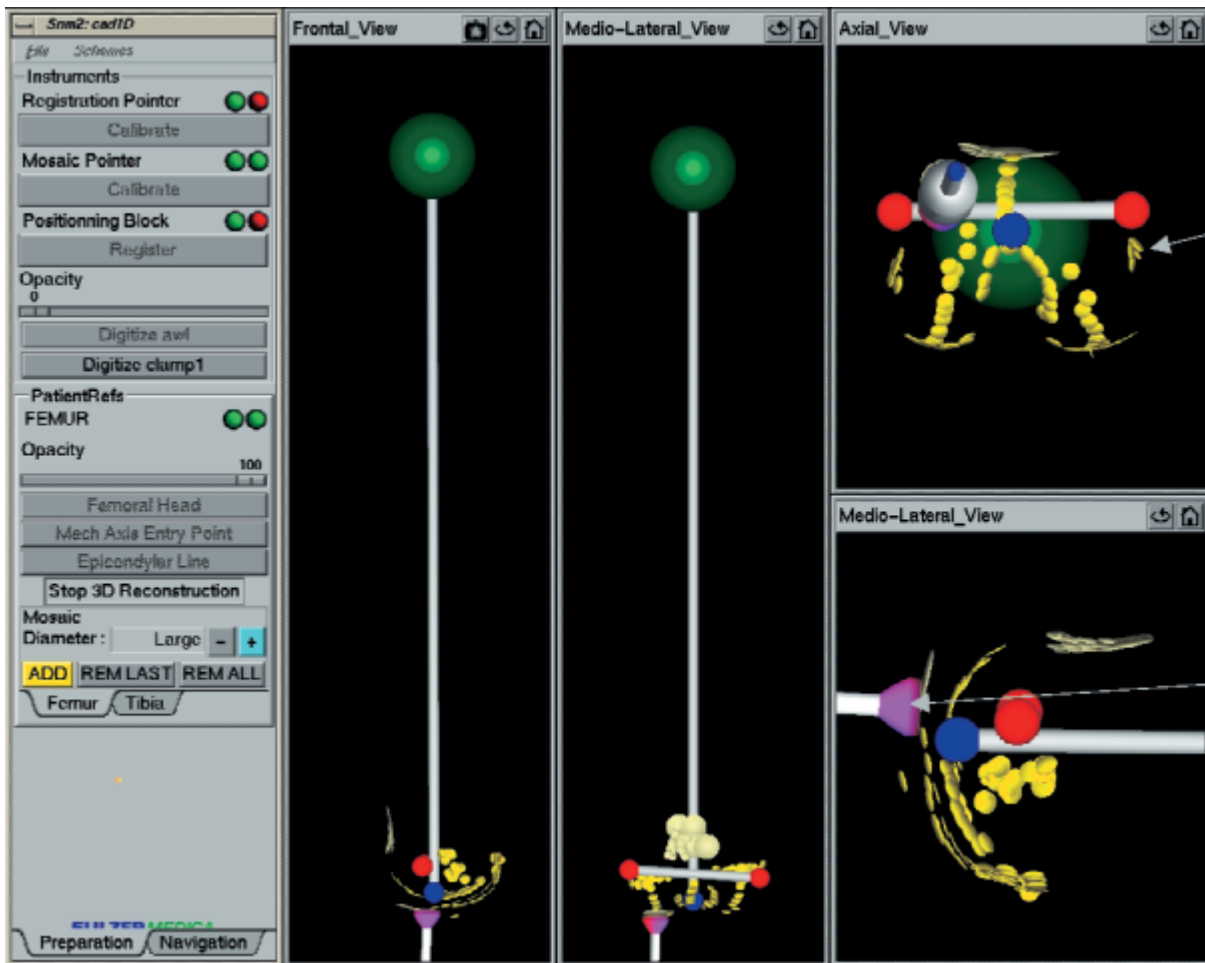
3D reconstruction from a CT-less system. The digitizer (pink) indicates the relevant surfaces necessary to implant the prosthesis. The longitudinal grey axis represents the mechanical femoral axis from the center of the femoral head to the center of the knee.
